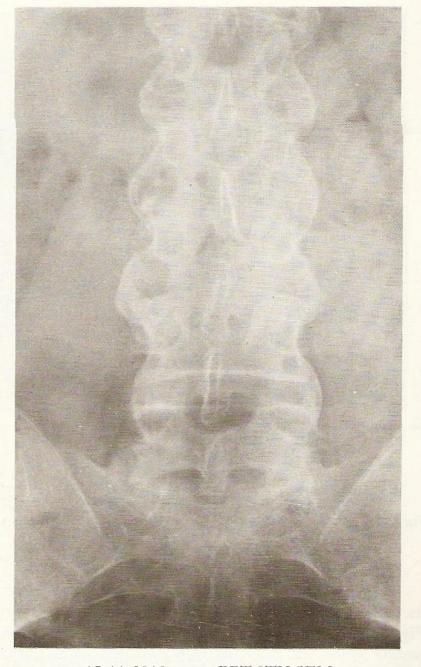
A.P. radiograph of the lumbosacral spine in advanced ankylosing spondylitis. The spinal ligaments are calcified giving an appearance similar to a piece of bamboo.
